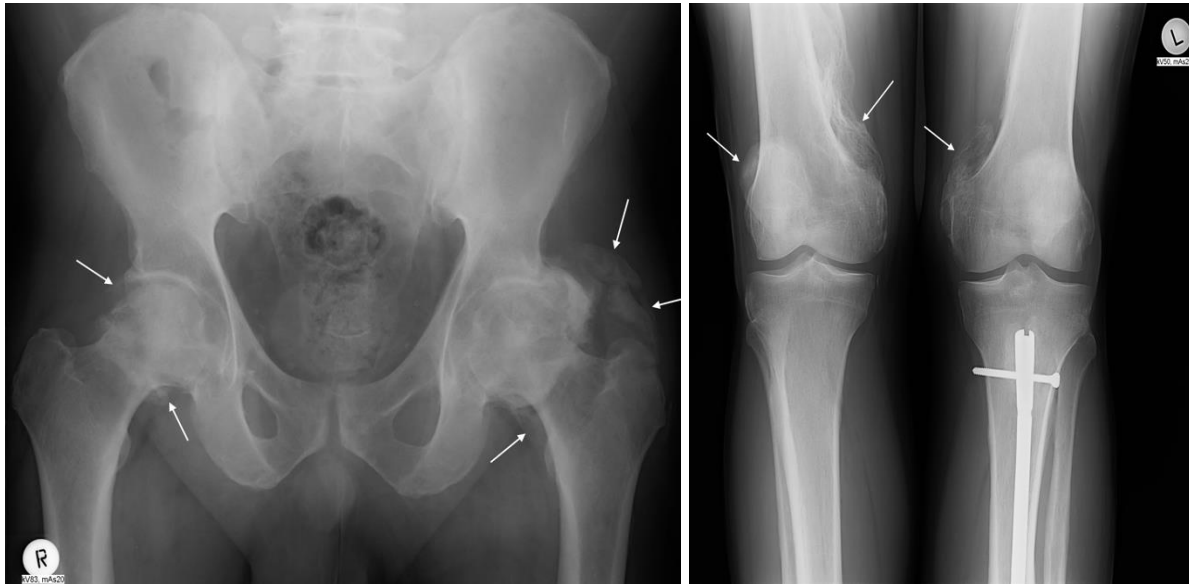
Anteroposterior projection X-rays of the hips (left) and knees (right) obtained on 20. 10. 2021, i.e. approximately 11 months post admission. Heterotopic ossifications (HOs) are seen bilaterally in both hip (left) and knee (right) joints as depicted by the arrows. On the left knee, an intramedullary nail can be seen following osteosynthesis performed in the year 2012 due to a tibial fracture.
